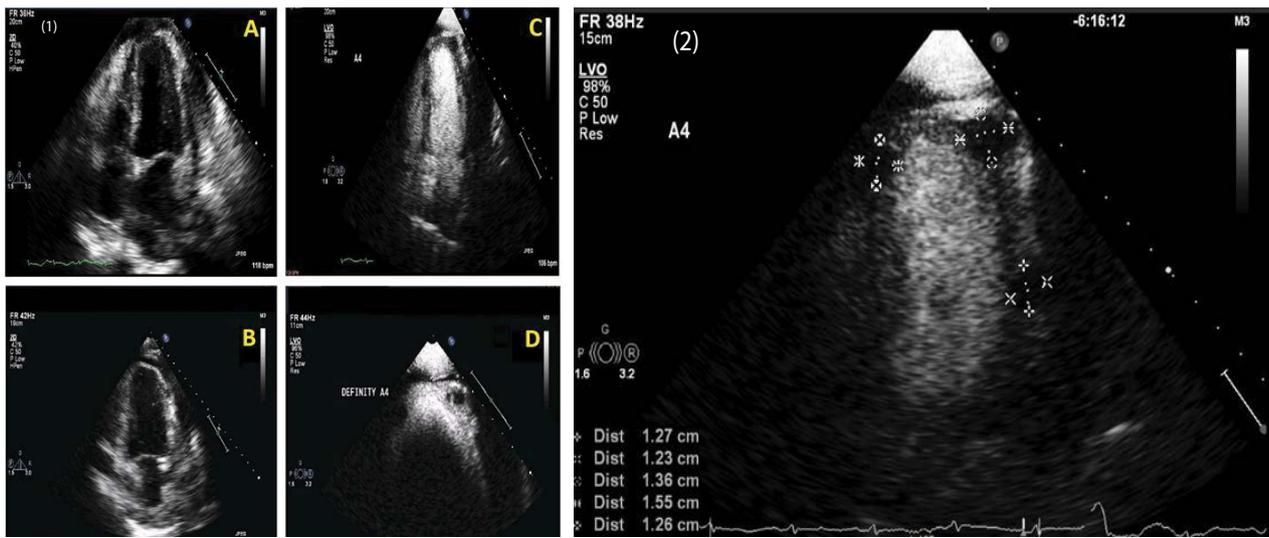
Transthoracic echocardiographic imaging. Images A and B gathered via echocardiography performed without contrast on day 1 following admission. Images C and D gathered via echocardiography performed with Definity intravenous contrast on day 2 following admission – highlighting intramyocardial masses.
